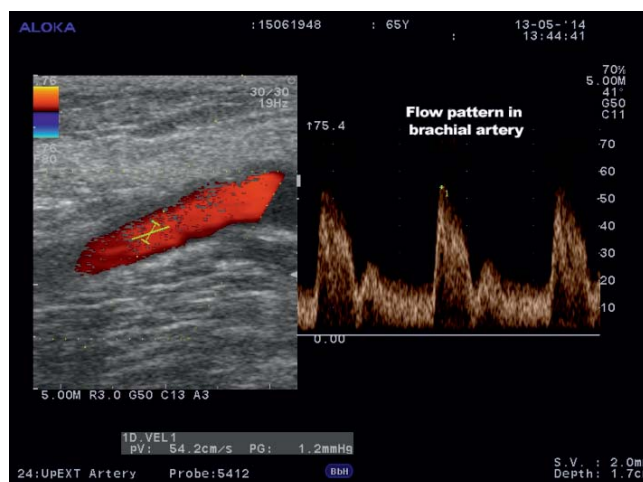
Color Doppler ultrasound of the brachial supplying artery indicating low-pulsatility pattern.
